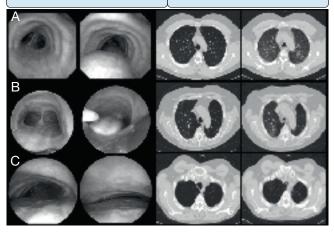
Dynamic bronchoscopy and correlating paired inspiratory-dynamic expiratory CT images in normal DAC (A), EDAC (B), and crescent type of tracheomalacia (TM) (C). In DAC and EDAC, the cartilage remains intact and of similar morphology during expiration as noted at bronchoscopy and CT (A and B), whereas in TM there is evident flattening of the anterior cartilaginous wall (C). See Figure 3 legend for expansion of abbreviations.
